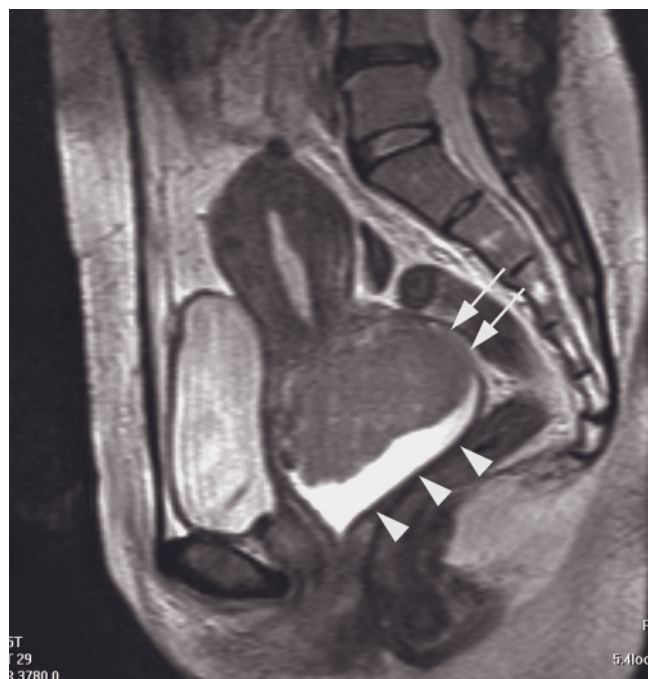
Cervical carcinoma with vaginal extension. Sagittal T2-weighted ETSE image shows hyperintense cervical carcinoma (arrow) with extension to the vagina. The tumor results in cervical stenosis with fluid retention within the uterus. Note that the fat planes between the cervix and the urinary bladder and between the cervix and the rectal wall are preserved (arrowheads), excluding bladder or rectal wall infiltration.
